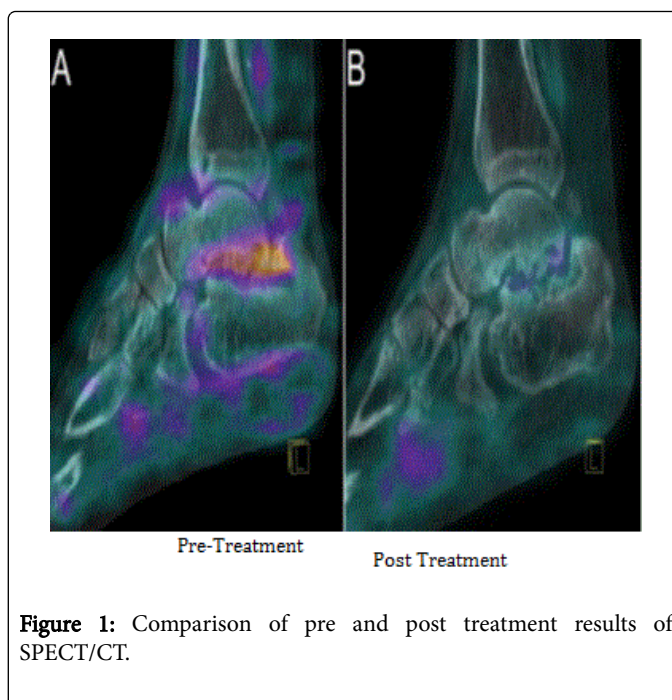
Comparison of pre and post treatment results of SPECT/CT.
